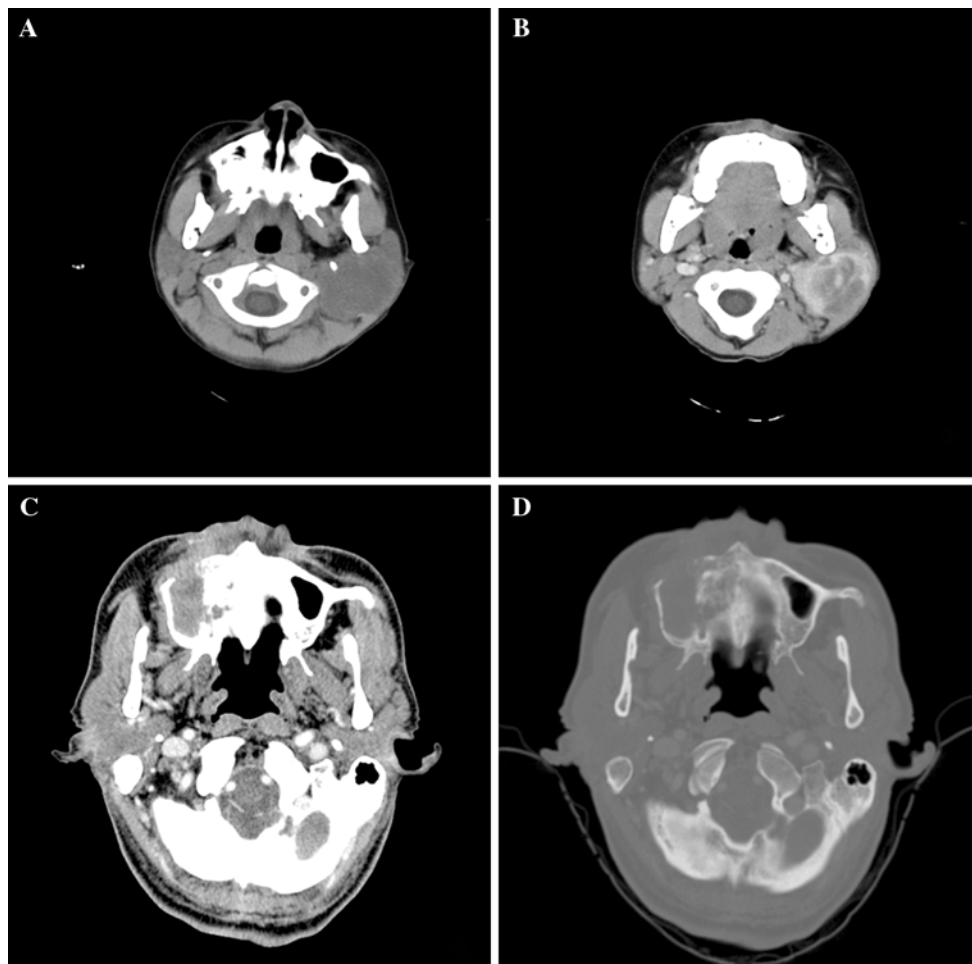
CT images of IMTs. a Heterogeneous density of the tumor in the deep lobe of the parotid gland extended into the left parapharyngeal space in unenhanced CT scan. b The tumor demonstrated marked heterogeneous enhancement in contrast-enhanced CT scan. c Soft
